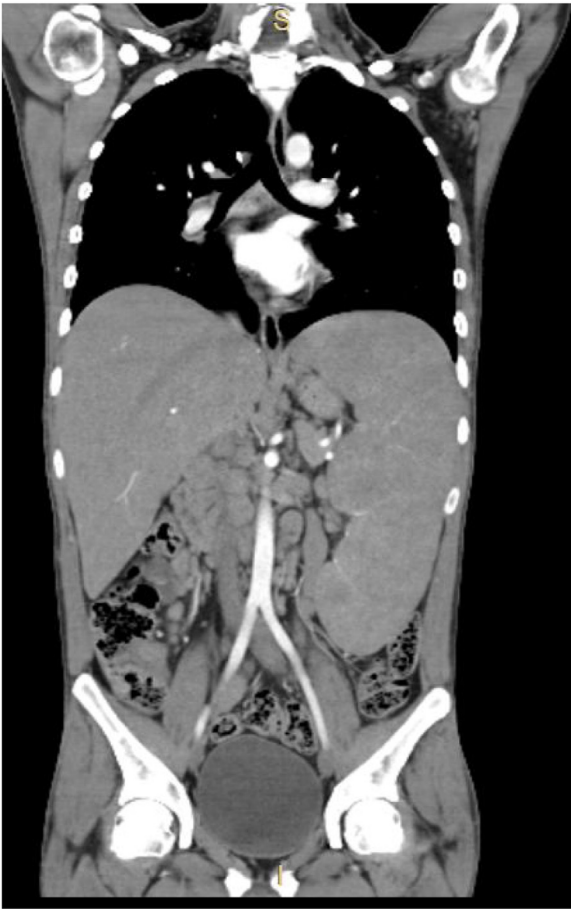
Coronal section of contrast CT scan with IV contrast, showing massive splenomegaly and multiple enlarged retroperitoneal nodes.
